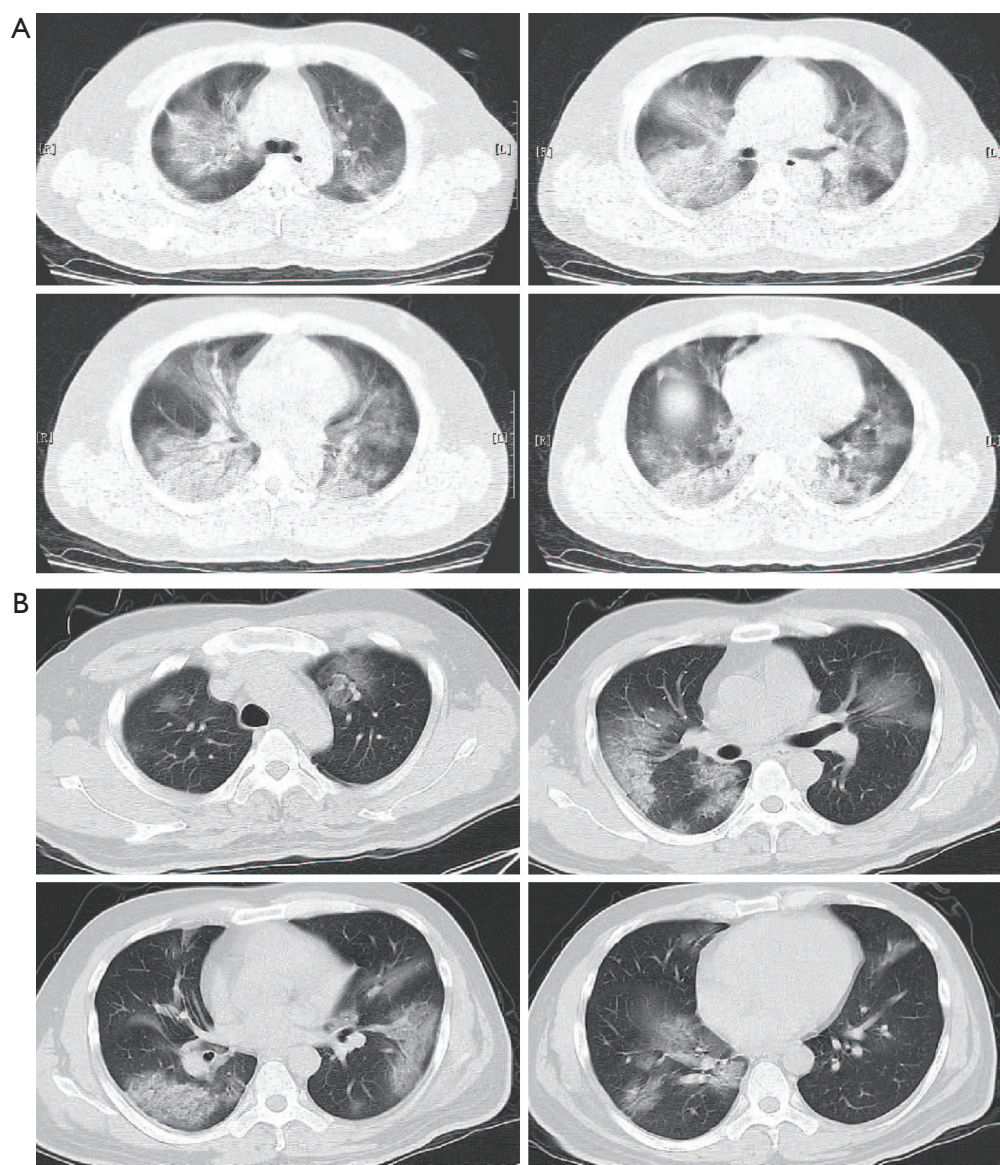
Chest computed tomography of critically ill COVID-19 patients. (A) In most critically severe cases, chest computed tomogram scans demonstrated bilateral diffuse ground-glass opacities, reticular pattern, and consolidation; (B) in most severe cases, the main patterns of abnormality on chest computed tomogram included localized ground-glass opacity of both lungs.
